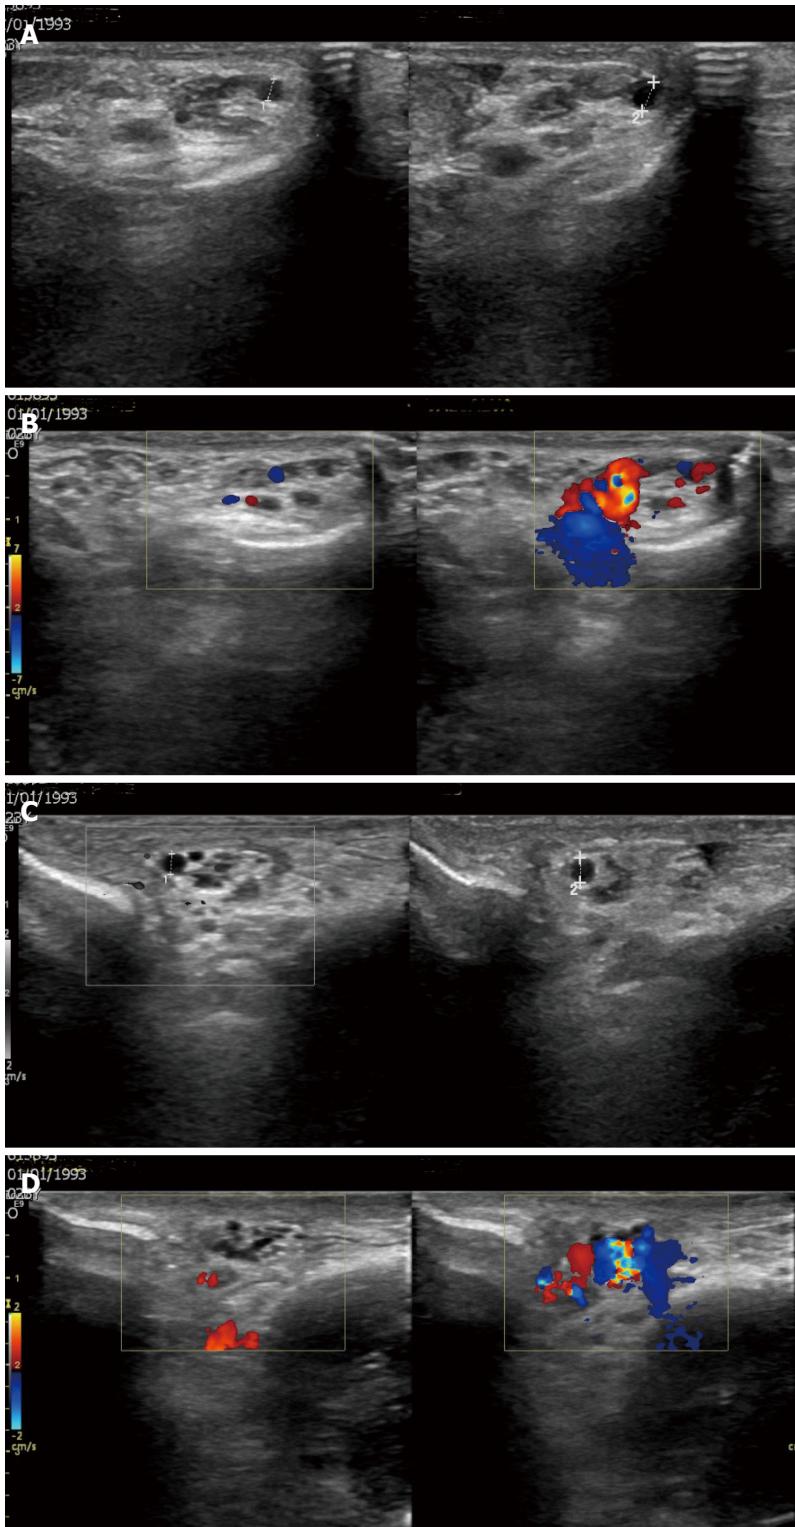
A 24-year-old man with bilateral varicocele. A: Gray-scale sonographic images, longitudinal sections at the supratesticular region of the left hemiscrotum at rest and during the Valsalva maneuver. The maximal diameter of the left spermatic veins is 2.5 mm at rest and 3.5 mm during the Valsalva maneuver; B: Color Doppler sonographic images, longitudinal sections same level show blood flow reversal after Valsalva maneuver; C: Gray-scale sonographic images, longitudinal sections at the right supratesticular region. The maximal diameter of the right spermatic veins is 2.3 mm at rest and 2.8 mm during the Valsalva maneuver; D: Color Doppler sonographic images, longitudinal sections show flow reversal with Valsalva maneuver.
